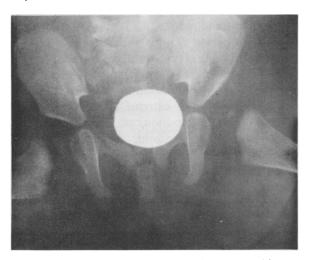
A frog-leg lateral view of the same hips as shown in Figure 6. This view shows the relative underdevelopment of the capital femoral epiphysis on the patient's left side. Delayed development cannot be detected until this ossification center becomes visible on x-ray studies, usually at 4 to 6 months of age. (Reproduced by permission from Specht EE: Am Fam Physician 9:88-96, Feb 74)
